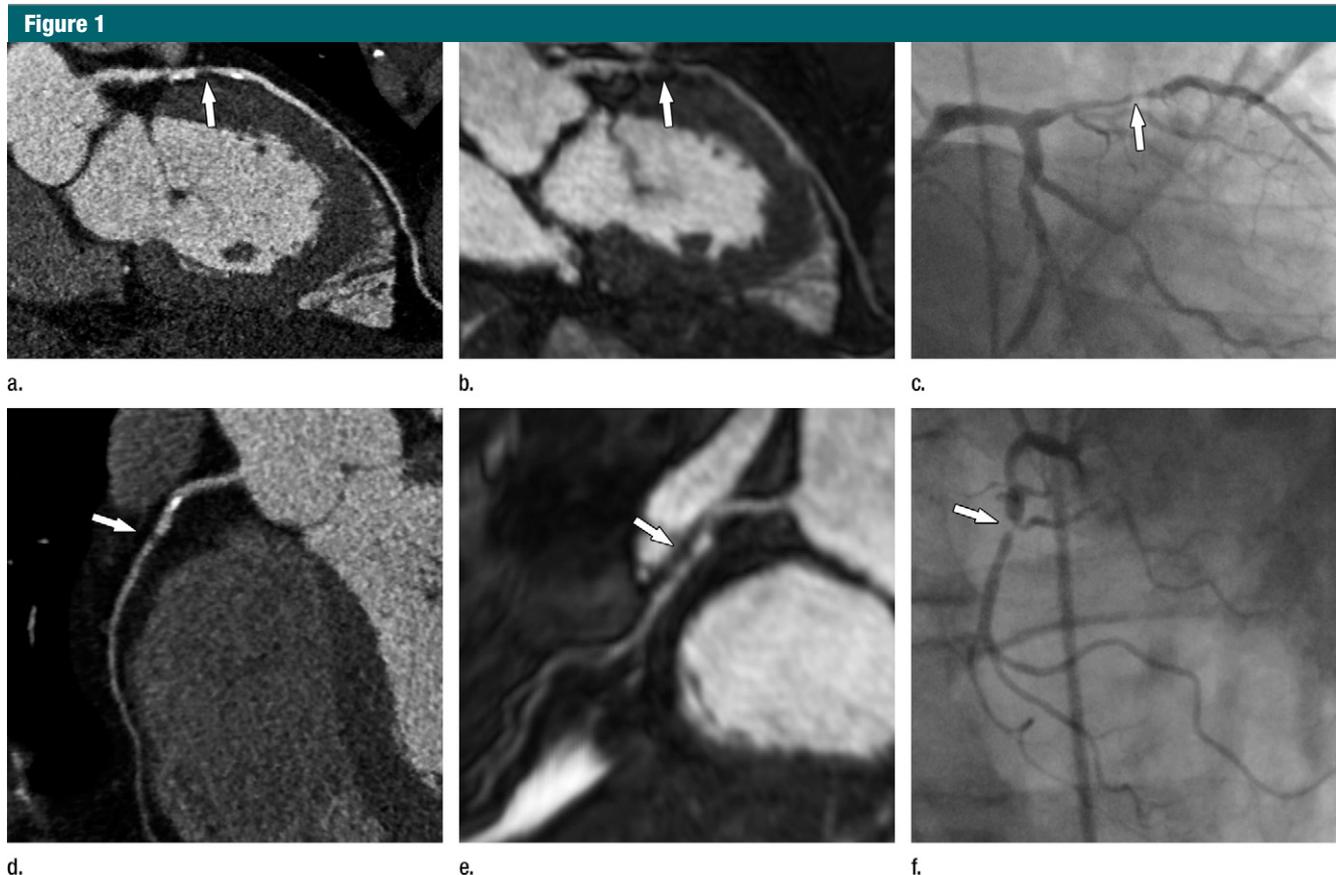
(a–f) Comparative performance of (a, d) CT and (b, e) MR imaging for detection of coronary artery disease (CAD) (arrow) in comparison with (c, f) conventional coronary angiography in a 55-year-old man with atypical angina pectoris. Images a–c show a significant stenosis in the middle left anterior descending coronary artery, and images d–f show a significant stenosis in the small right coronary artery in the middle segment. Images were obtained by using 320–detector row coronary CT angiography and whole-heart coronary MR angiography with 32-channel technology. Noninvasive coronary images are reconstructed as curved multiplanar reformations. The spatial resolution of CT is greatly superior to that of MR imaging.
